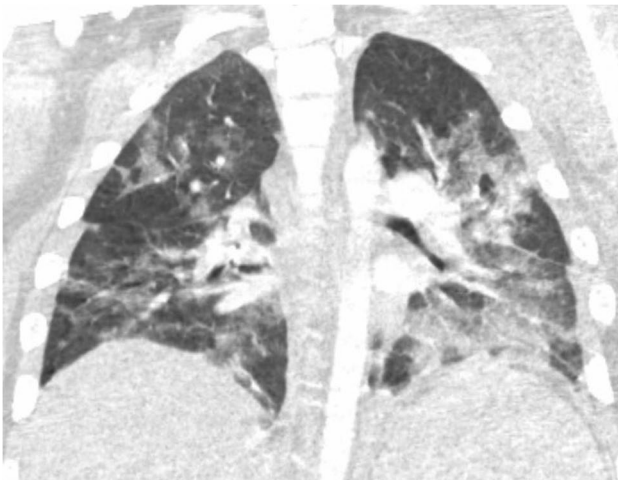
CT findings in a 13-year-old boy with acute coronavirus disease 2019 (COVID-19) pneumonia who presented with fever, dyspnea and chest pain. Coronal chest CT image in lung window demonstrates multiple peripheral and central ground-glass opacities throughout both lungs
